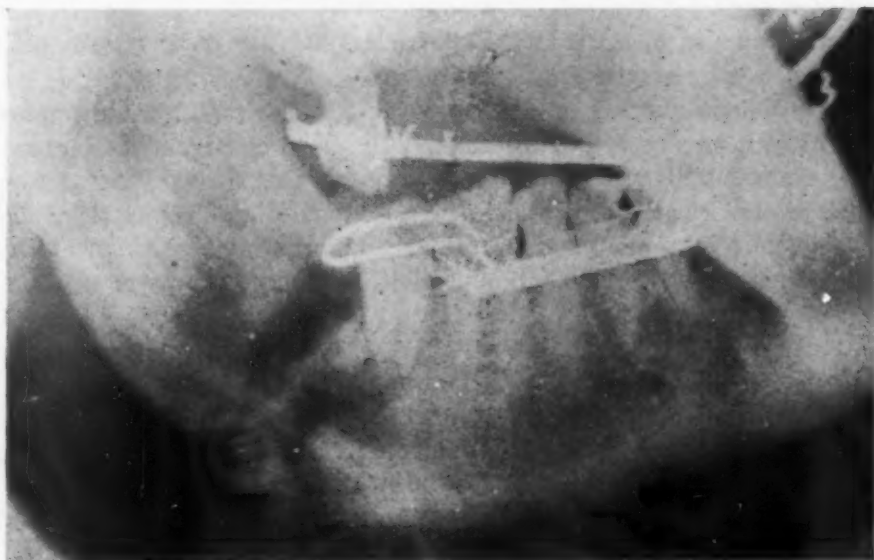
X-ray of patient's jaw shows osteomyelitis in fracture line and involved tooth.
